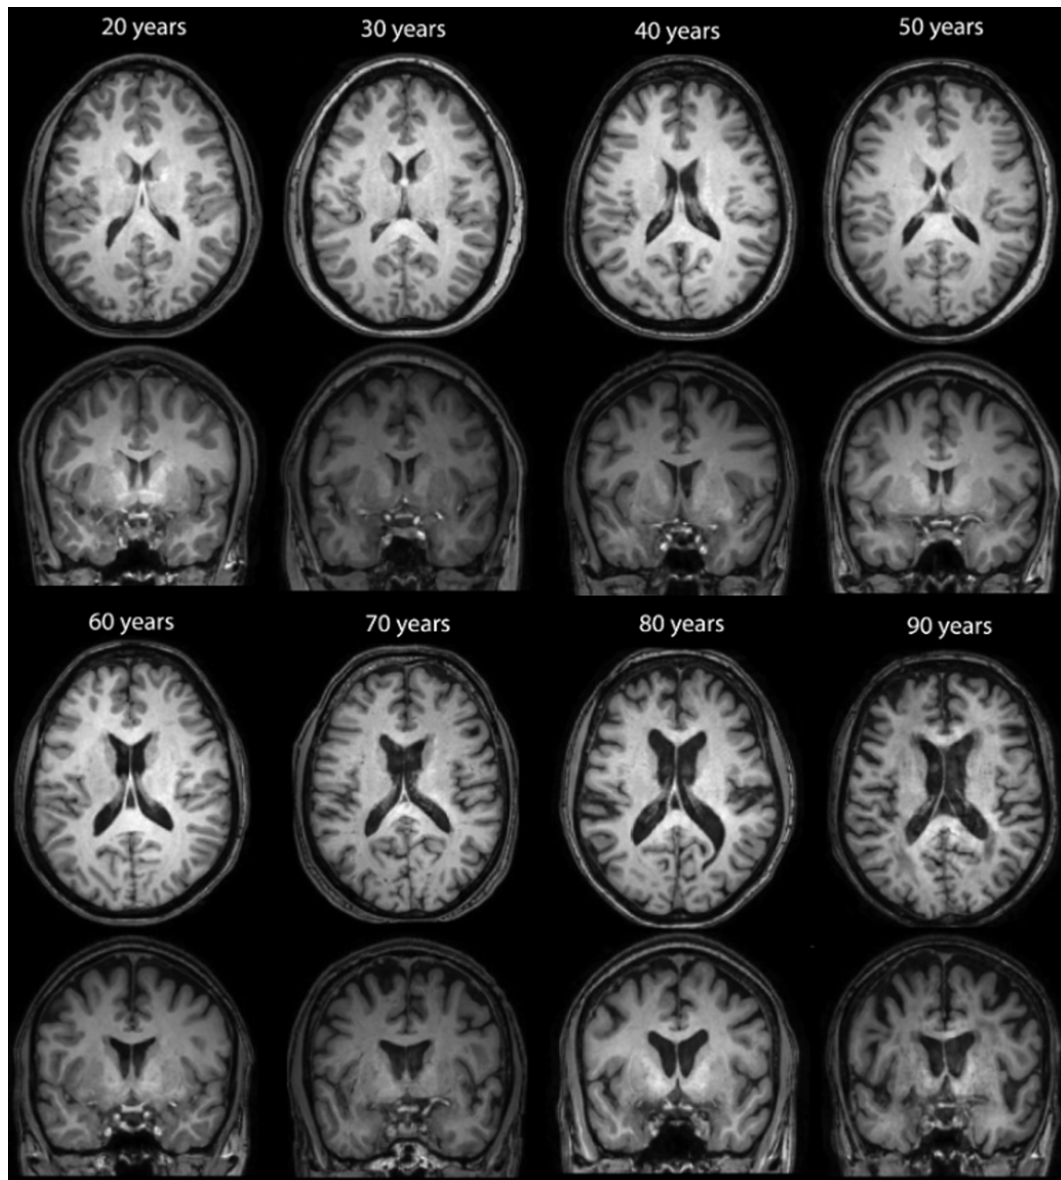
MRI images showing the degree of brain alterations, including atrophy, across the lifespan. Taken from [7].
